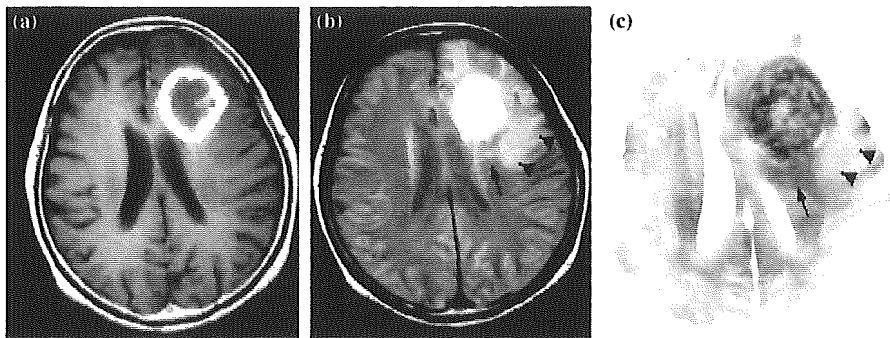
Conventional MRI and 3DAC in Case 7. (a) Gd-T1WI shows glioblastoma situated in the left frontal lobe. (b) PDWI demonstrates hyperintense foci, with corona radiata behind the tumor bulk (arrow), as the responsible tract, and subcortical white matter surrounding the tumor bulk (arrowhead). (c) 3DAC demonstrates slight darkness on the corona radiata (arrow), whereas white matter surrounding the tumor bulk displays faint coloration (arrowhead). The tumor bulk is darker than the responsible tract.
